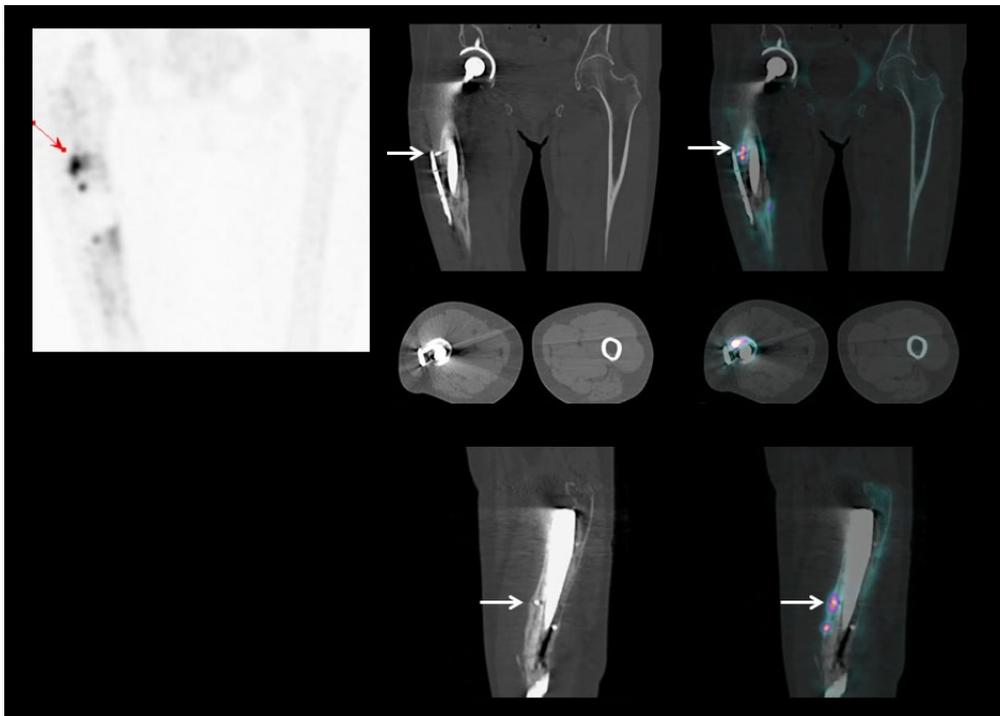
CT and fused SPECT/CT images highlight the extruded proximal screw with associated hypermetabolism related to shear stress secondary to screw loosening and extrusion (white arrows).
